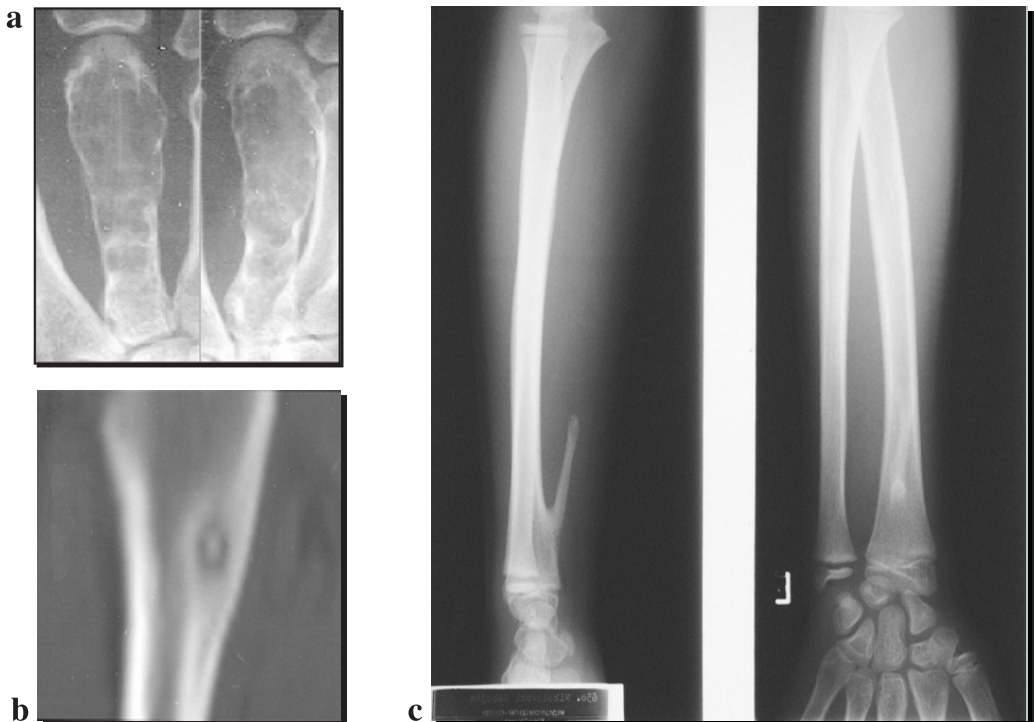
(a) enchondroma in the proximal phalanx of the third finger of the hand, presented with moderate pain until the fracture occurred; (b) CT imaging of osteoid-osteoma in the proximal femur, with typical "nidus"; (c) plain radiograph of the forearm showing osteochondroma of distal radius (almost not seen in frontal plane).
